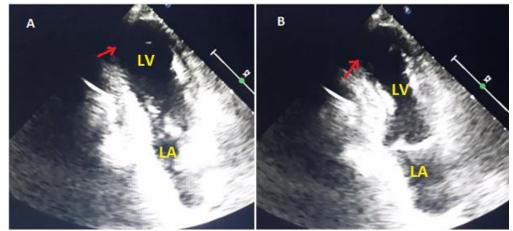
Apical two chamber echocardiography view shows the left ventricle in diastolic phase (A) and systolic phase (B) revealing severe dysfunction of the apex (red arrows). LV: left ventricle, LA: left atrium
